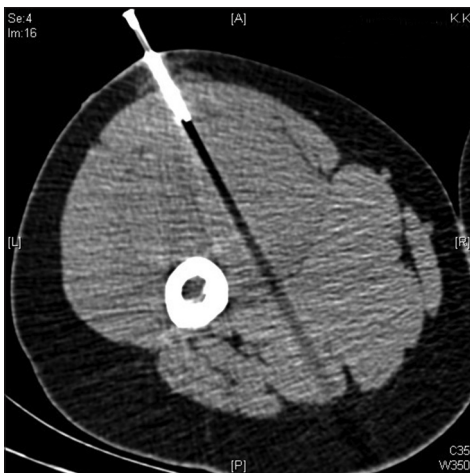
Computed tomography guided core-needle biopsy of a left thigh, in Ewing's sarcoma
